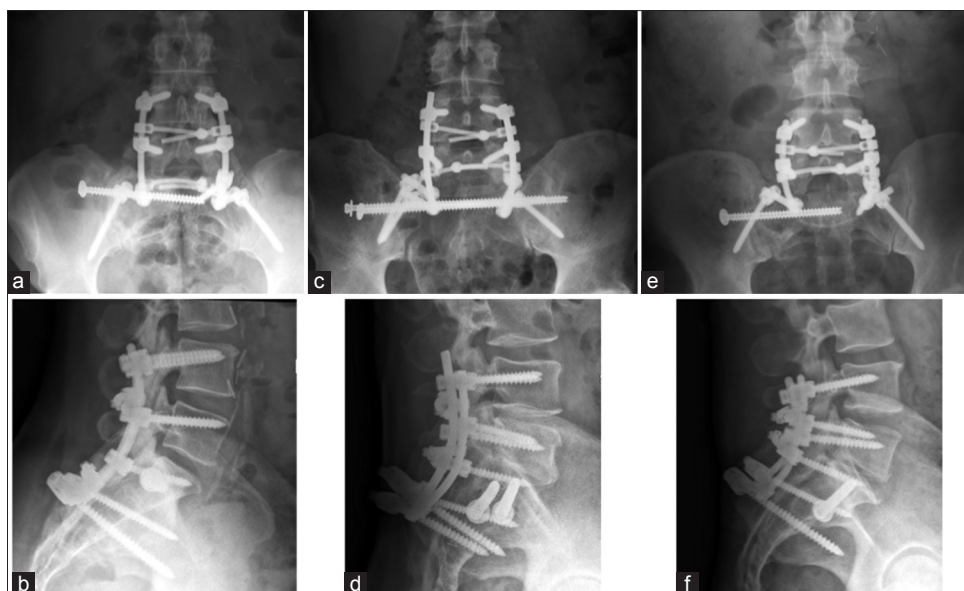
Postoperative X-rays of Case 1 (a and b), Case 2 (c and d), and Case 3 (e and f)
